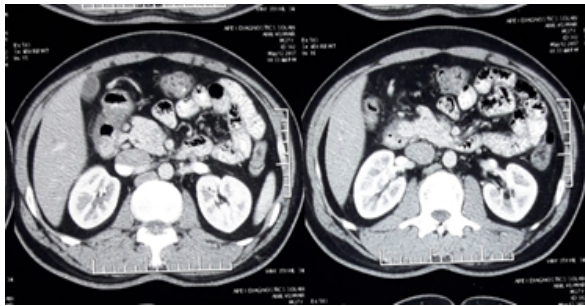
CT scan showing thickening of the first part of duodenum.
